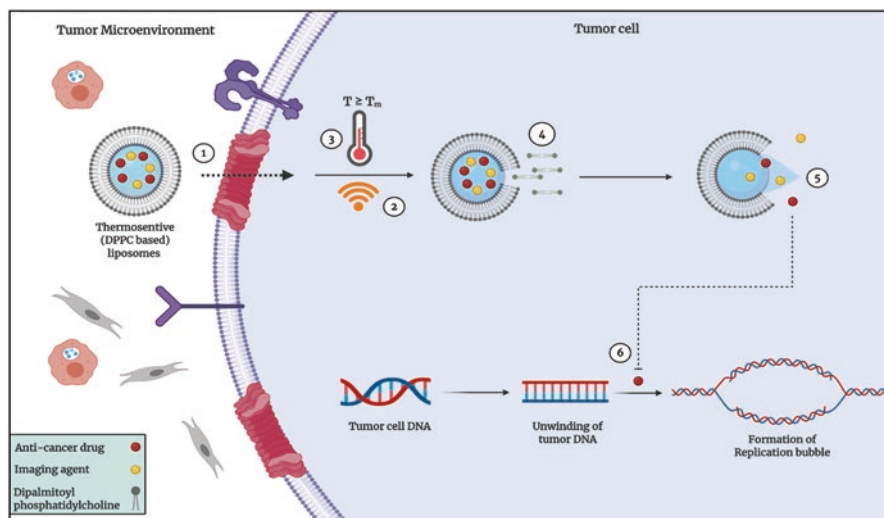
DPPC-based TSL for targeted and intra-tumor delivery of theranostics. (1) ERP mediated TSL internalization in tumor cells. (2) Incidence of high-frequency focused ultrasound (HIFU). (3) HIFU-mediated mild hyperthermia to achieve temperature about $42\text{ }^{\circ}\text{C} > T_m$. (4) Hyperthermia ($42\text{ }^{\circ}\text{C}$) causes either the transition of gel phase DPPC into a crystalline liquid state or the formation of CO_2 bubbles that disrupt lipid bilayer. (5) Release of entrapped content due to membrane destabilization owing to erstwhile mentioned DPPC transition. (6) Inhibition of tumor cell DNA replication through the release of entrapped anti-cancer drugs
